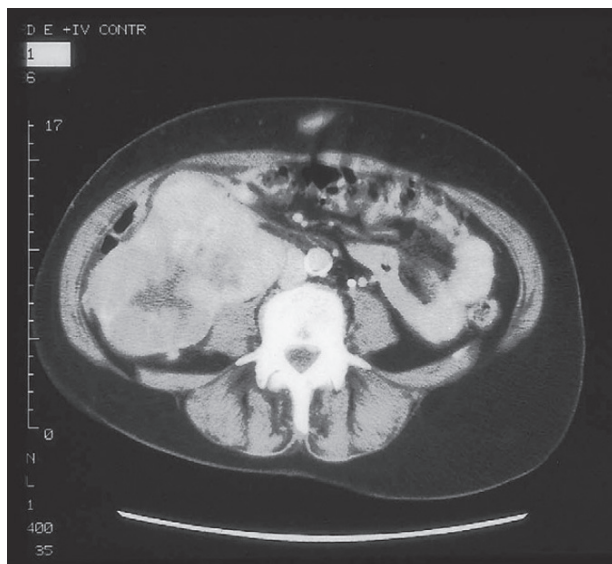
Abdominal CT scan. There is a renal cell carcinoma of the right kidney.
